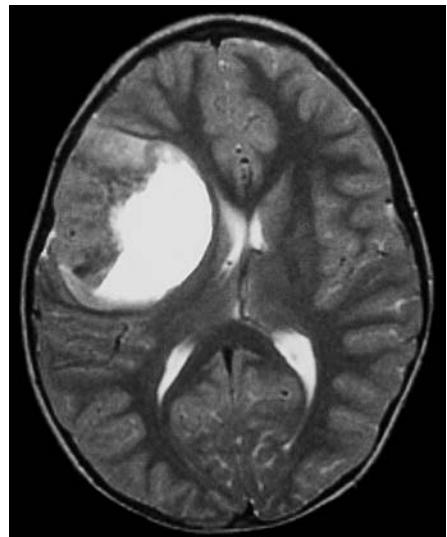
Enhanced, T1-weighted MRI of a large, cystic supratentorial atypical teratoid/rhabdoid tumour.
